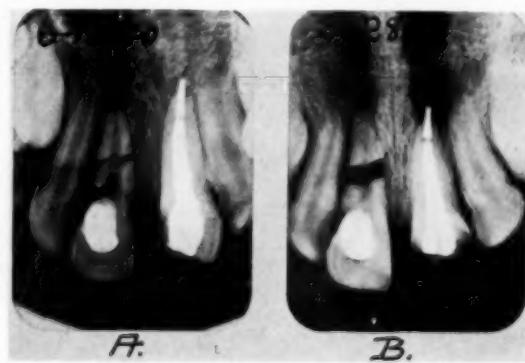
Roentgenograms of a fractured upper right central incisor in a 10-year-old child. *A*, X-ray taken about two months after the accident. *B*, X-ray taken nine months later. Note the supra-eruption in *B*, probably caused by an inflammatory reaction at the site of fracture between the coronal and apical segments. (Courtesy of Dr. Elsie Gerlach.)
